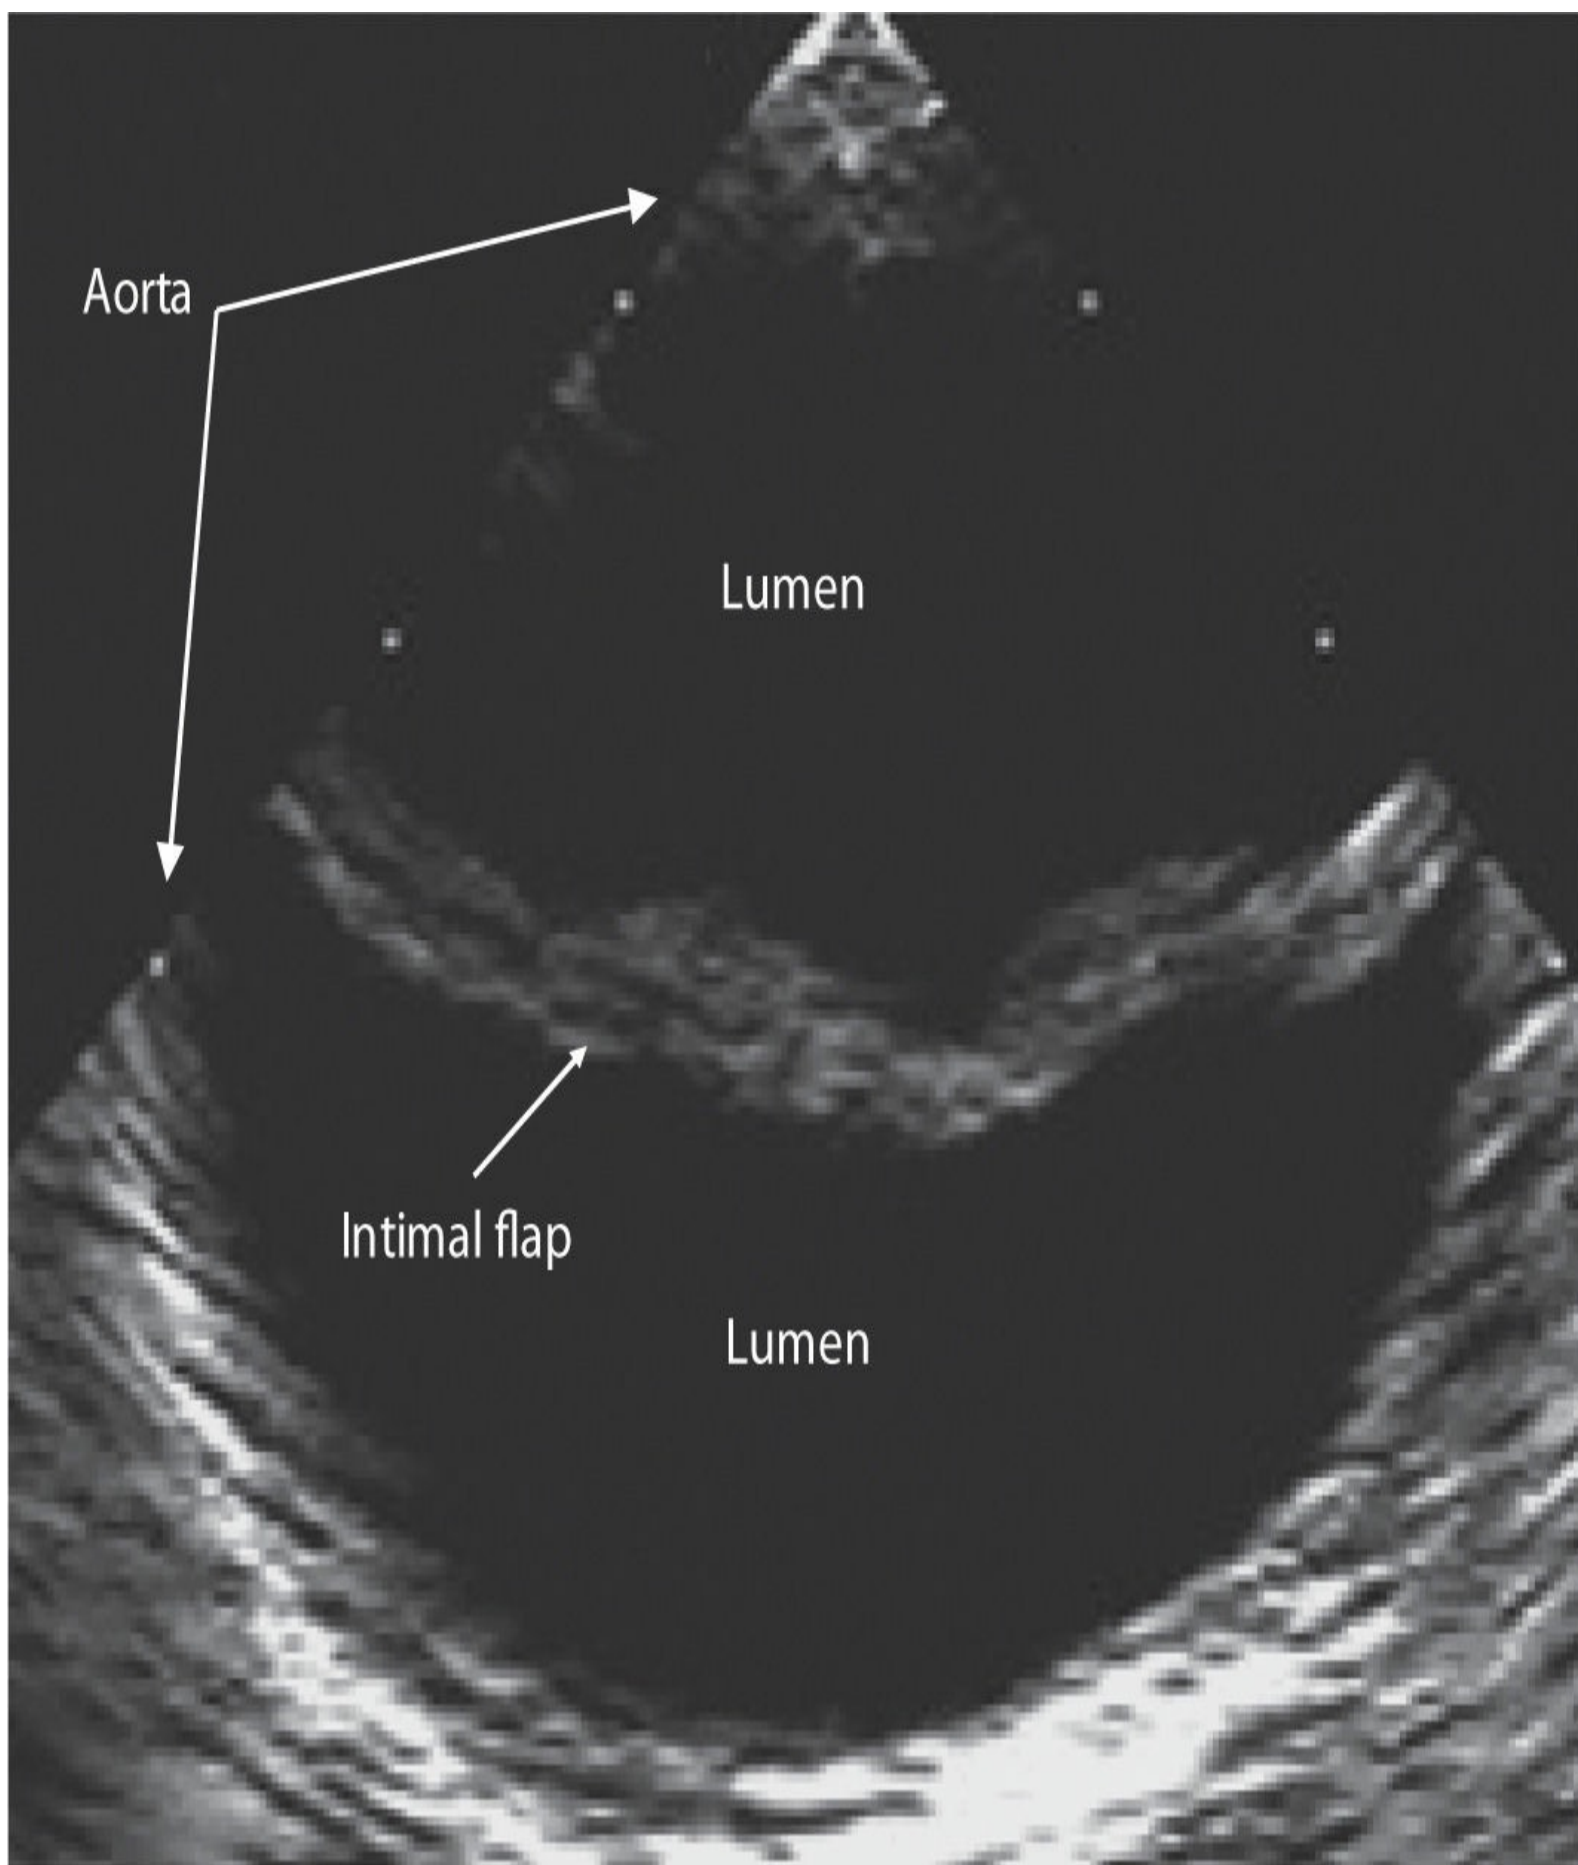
Aortic dissection. Transesophageal image demonstrating an intimal flap separating two aortic lumina. The true versus the false lumen cannot be determined by this single image. (Reproduced, with permission, from Pahlm O, Wagner GS, eds. *Multimodal Cardiovascular Imaging: Principles and Clinical Applications*. New York: McGraw-Hill; 2011.)
